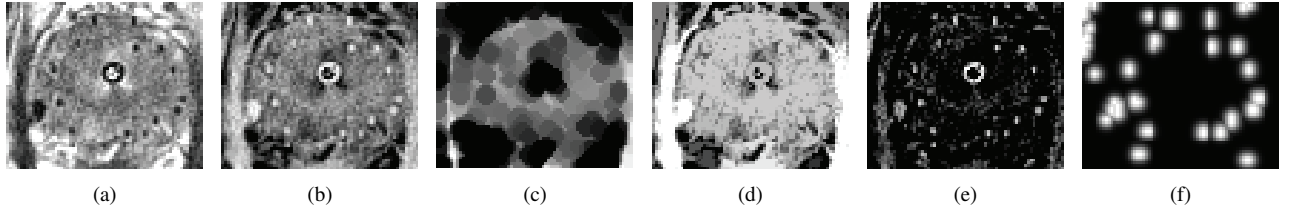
MR image processing steps: (a) original slice (contrast changed for better visualization), (b) negated and thresholded slice, (c) eroded slice, (d) reconstructed slice, (e) the difference between the mask and the reconstructed images, (f) Gaussian blurred image. Note that the catheter in is removed in (f).
